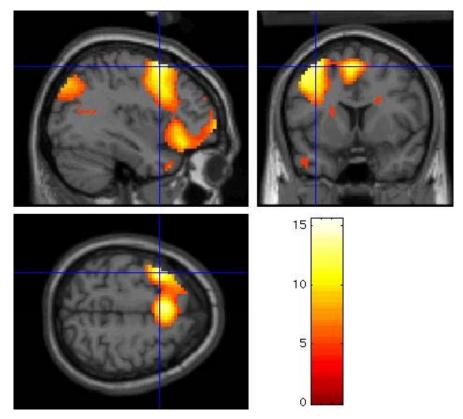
Relative increases in neural activity associated with positive, negative, and stressful remembrances (compared to rest) superimposed on MRI sections to depict the functional anatomy of the activations and their relationship to the underlying structural anatomy.
